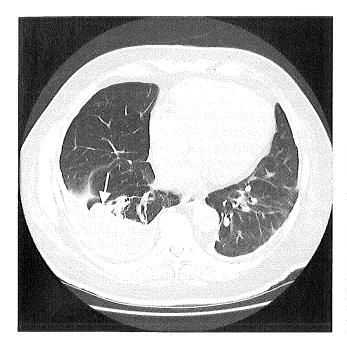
Chest CT showing rounded atelectasis (*arrow*) with its typical findings of a round area of lung parenchyma associated with a pleural abnormality and a comet tail that extends into the lung parenchyma.
